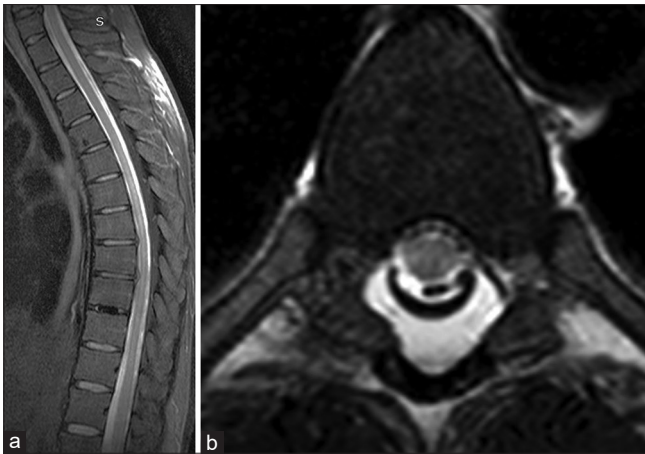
(a and b) Follow-up study after 6 months. T2-weighted image of the spine reveals markedly decreased symmetrical nonenhancing high-signal areas in the posterior columns
